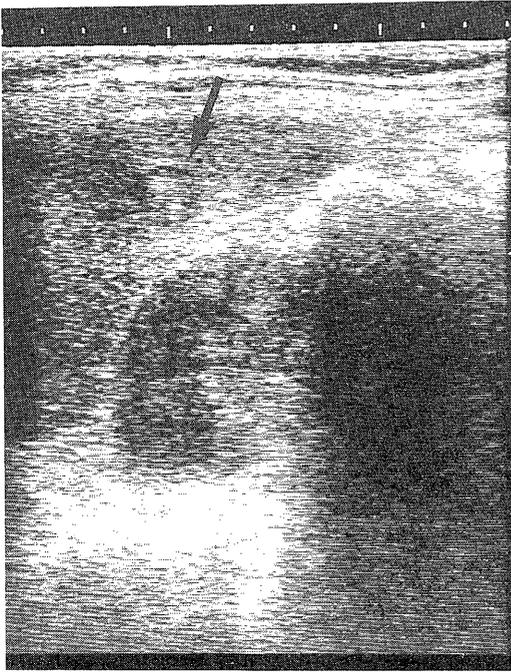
Preoperative ultrasonogram of small HCC showing 1.5×1.7 cm hypoechoic lesion (arrow) with a sonolucent thin rim or periphery around it.
